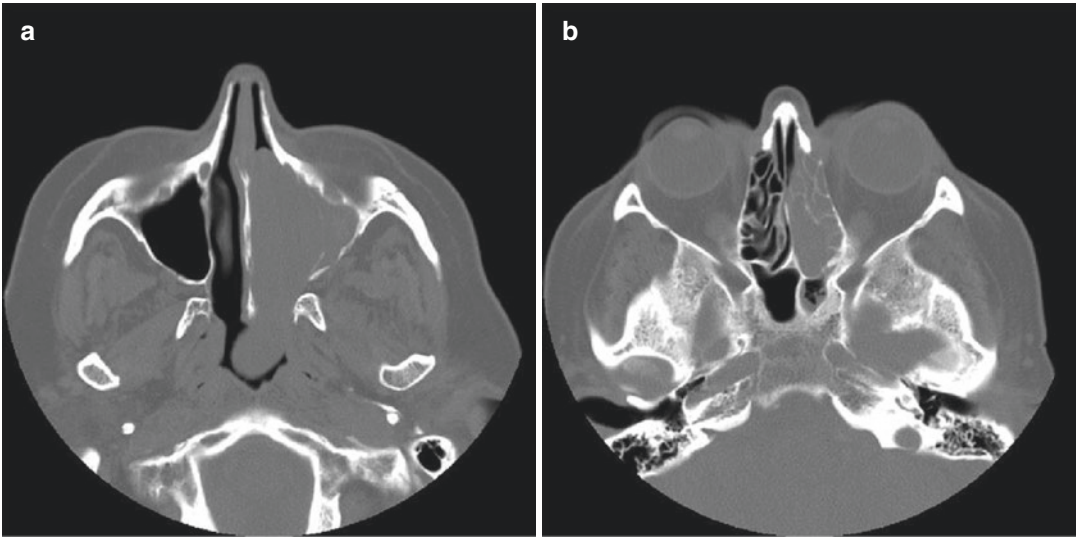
Axial CT scans (a) CT scan showing a mass in the left nasal cavity, and (b) CT scan showing the mass in the left ethmoid sinuses, The mass was initially thought to
